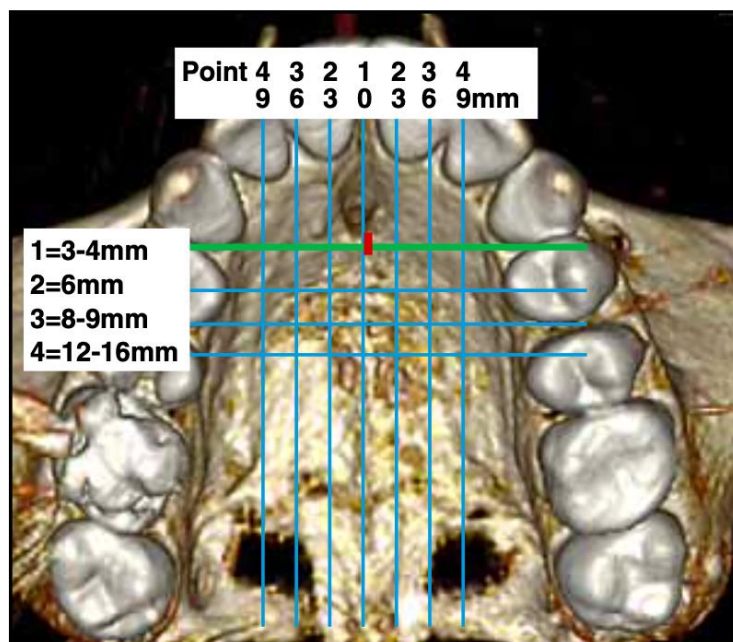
Palatal grid used in the analysis of radiographic and clinical findings (green line: anterior limit within which to insert a palatal miniscrew; red line: distance of the incisor foramen from the reference line)<sup>46</sup>
